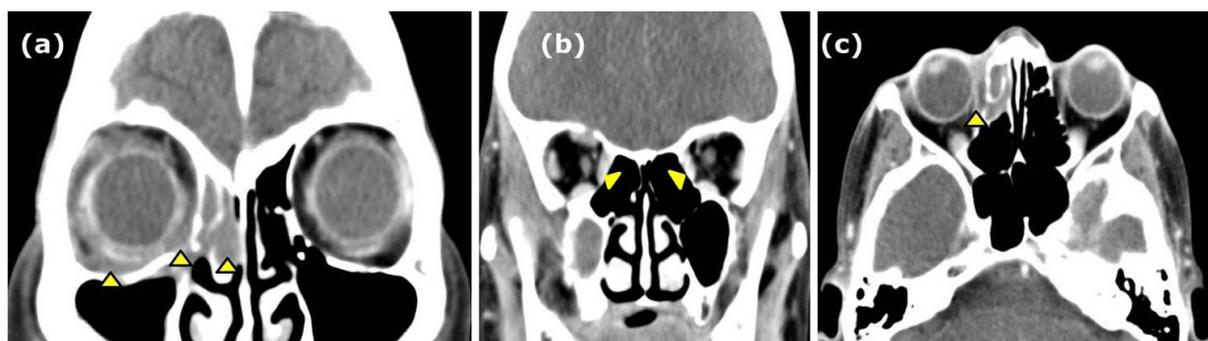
Contrast enhanced CT images during mid cycle chemoradiotherapy. (a) Coronal image at the level of mid globe showed reduced tumour size with residual tumour (yellow arrowheads) at the inferomedial of right orbit and extended to right ethmoid sinus. (b) Coronal image at the posterior part of the orbit showed the rectus muscles (arrowhead) are symmetrical bilaterally. (c) Axial images showed the lesion (yellow arrowhead) is smaller at the medial aspect of the right globe and extension to the ethmoid sinus. Her previous right proptosis had resolved in this study. (Click on image to enlarge).
